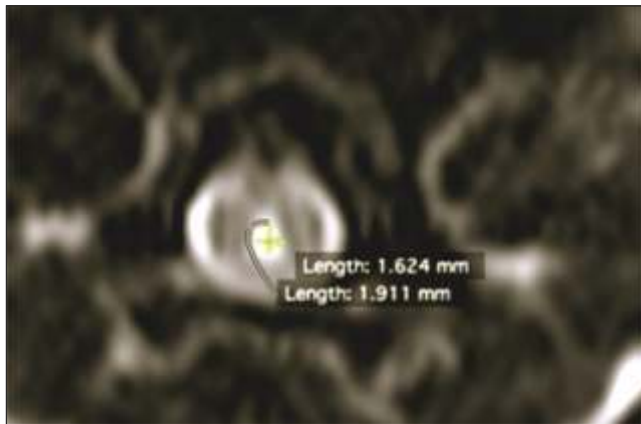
T2-weighted MRI image of the spinal cord, transverse plane. Note the presence of a fluid filled cavity with an interior diameter less than 2mm – classified as Grade 1 SM
